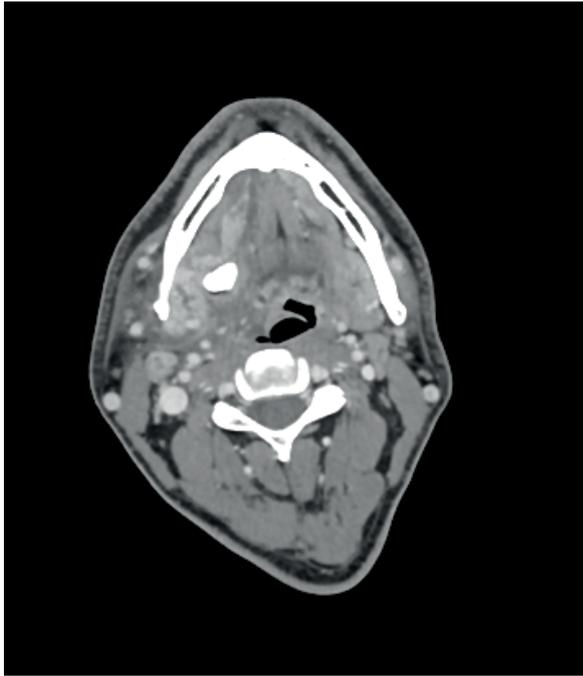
CT image of the submandibular gland (calculi on the right side)
